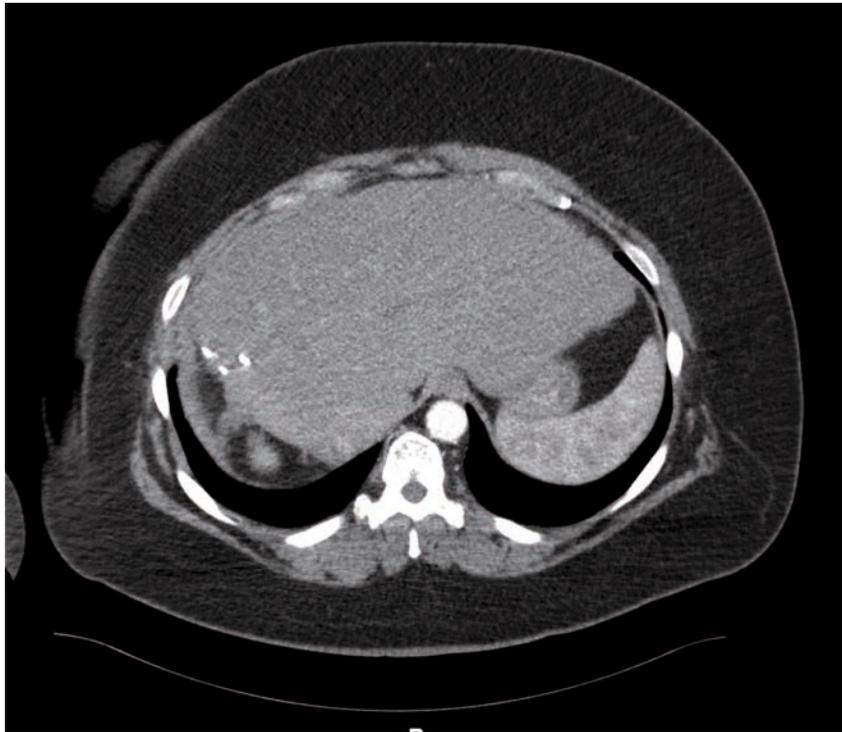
CT scan of liver post-treatment. No evidence of disease 1-year post-chemotherapy/spheres/surgery.
